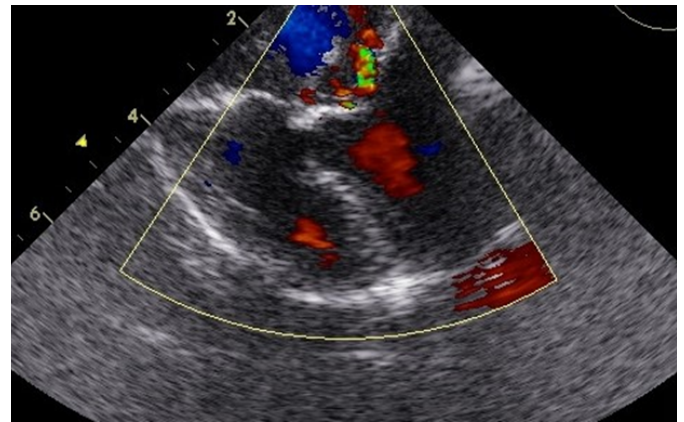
Post-correction transesophageal echocardiogram of twin 2 showing good surgical result, with mild right and left AV regurgitation.
